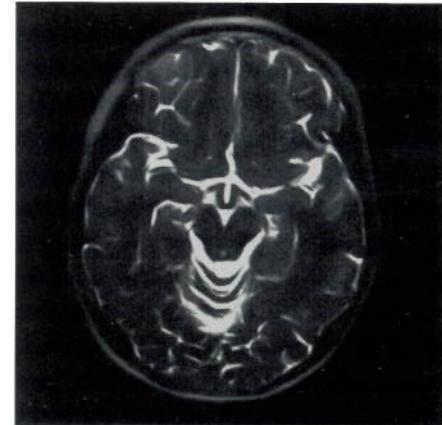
Ultrafast HASTE T2-weighted pediatric head, sequence used was haste240_87b260.wkc, TR 10.9 ms, TE 87 ms, Flip 180 deg, FOV 200 mm, no RecFOV, Swap, matrix 240h x 256o, slice 5 mm, 1 acquisition, scan time 26 sec, F:9 image filter. (Courtesy of Childrens Hospital of Philadelphia)
